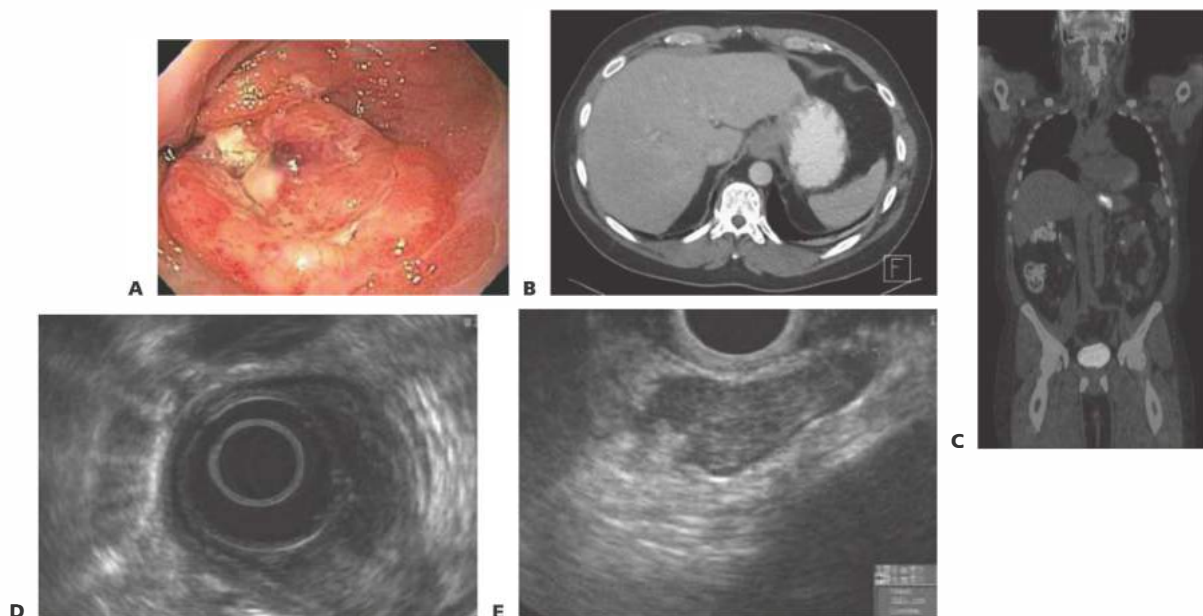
• Imaging and diagnostic evaluation of a patient with a localized T3, N1, M0 Siewert type 2 GE junction adenocarcinoma undergoing consideration for THE. A. Upper endoscopy showing ulcerated mass in the lower third of the esophagus. B. CT showing an enlarged mass at the lower third of the esophagus. C. PET-CT. D. Endoscopic ultrasound showing mucosal-based mass invading into the adventitia of the esophagus. E. Endoscopic ultrasound showing enlarged lymph node fine needle aspiration (FNA) biopsy confirming adenocarcinoma.
